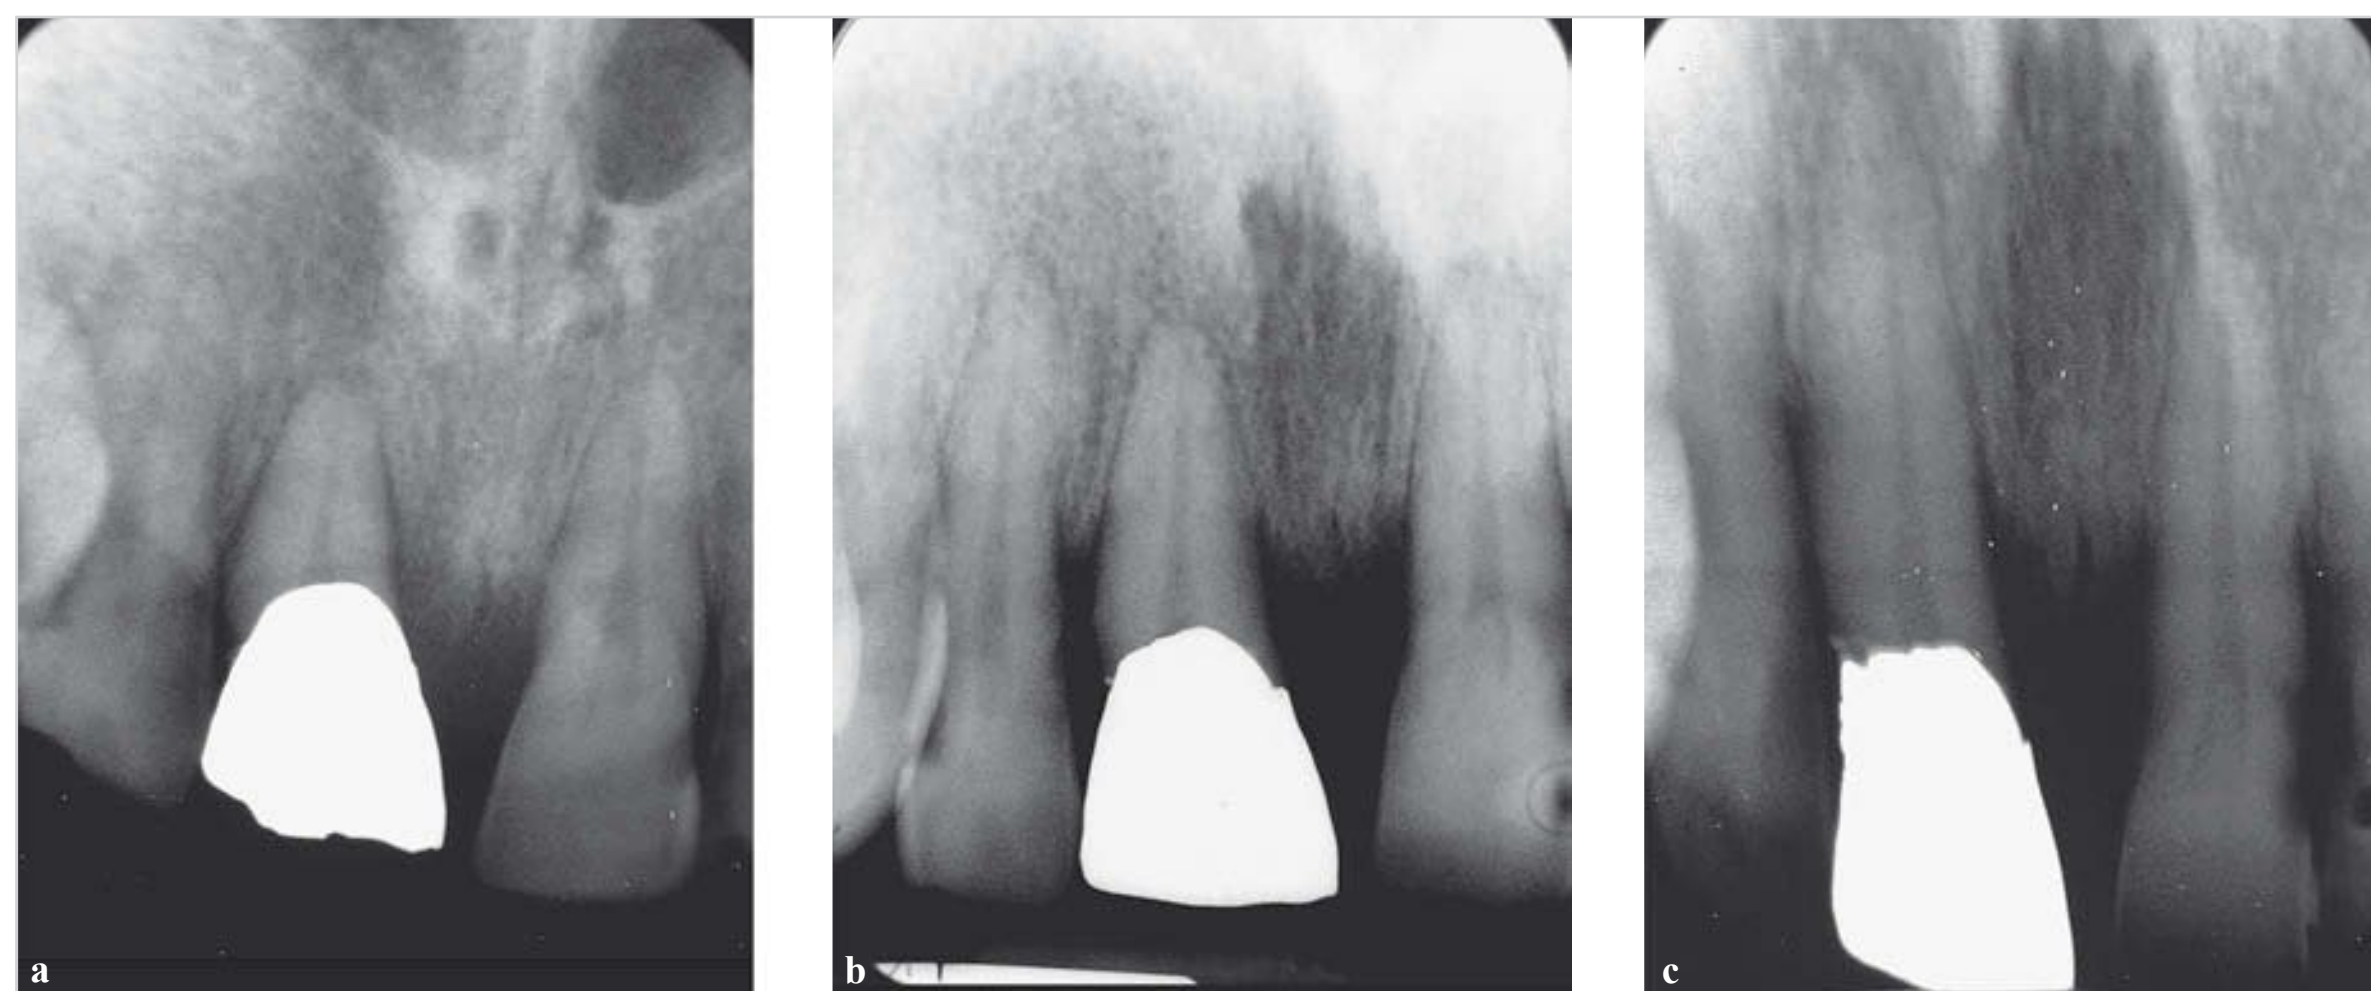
Comparison of three periapical radiographs.
